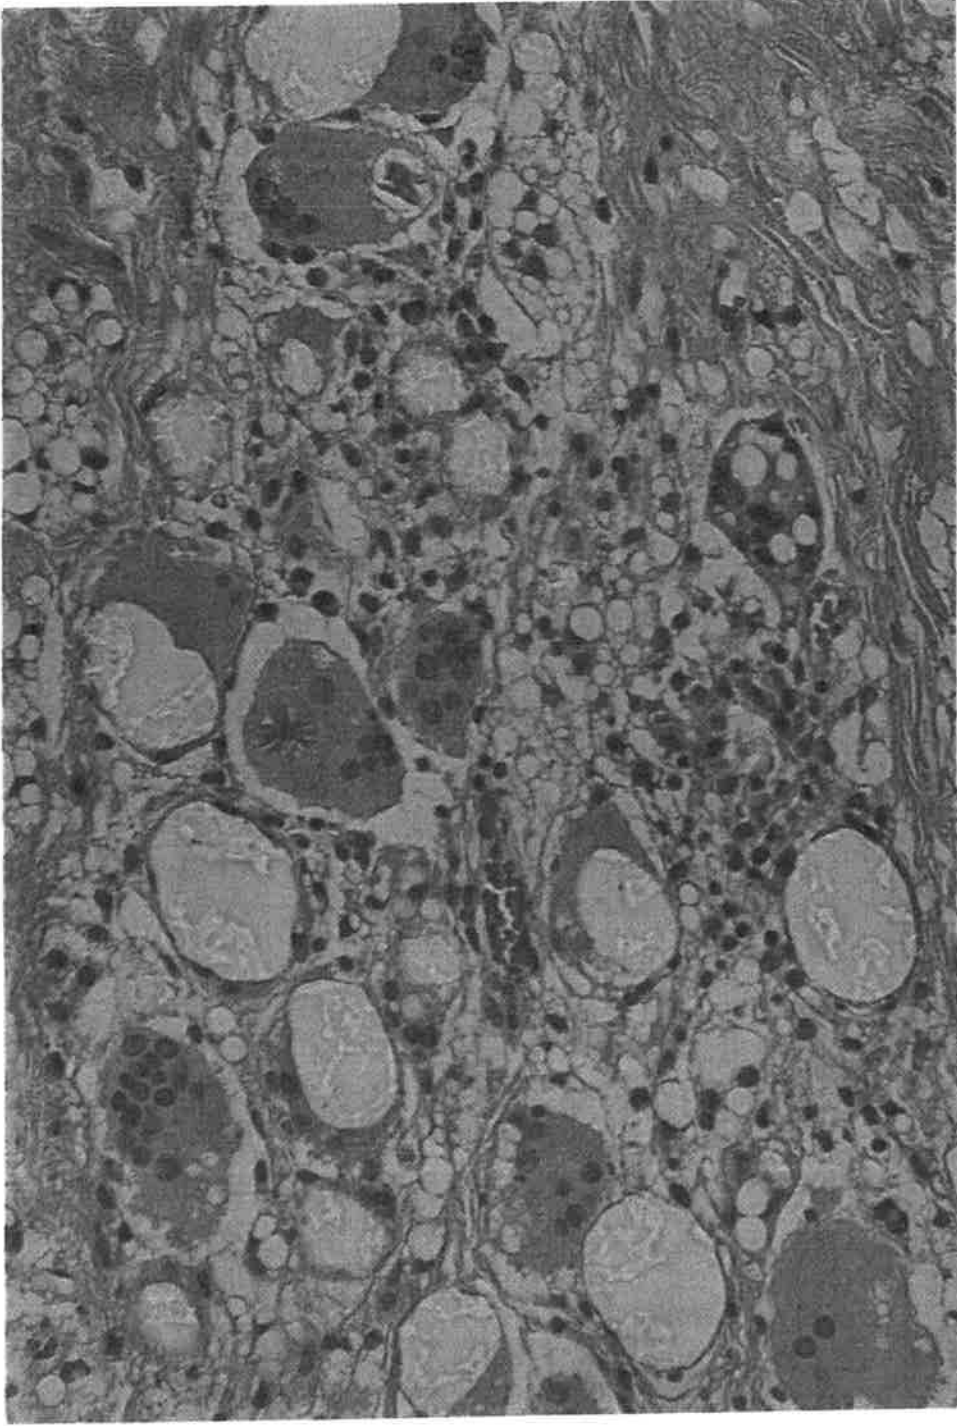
Section of a fibrous capsule showing large vacuoles containing silicone material identified by Energy-Dispersive X-ray Analysis. Inflammatory cells present are: lymphocytes, multinucleated giant cells, and plasmacytes (gel-filled prosthesis; implantation time: 16 years).
